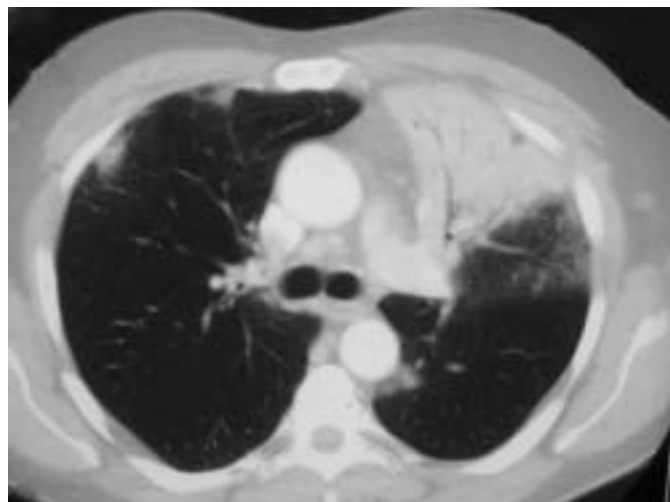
High-resolution computed tomography showing typical cryptogenic organising pneumonia with consolidation in the left-upper lobe with an air bronchogram. Of note are two small contralateral subpleural opacities.
